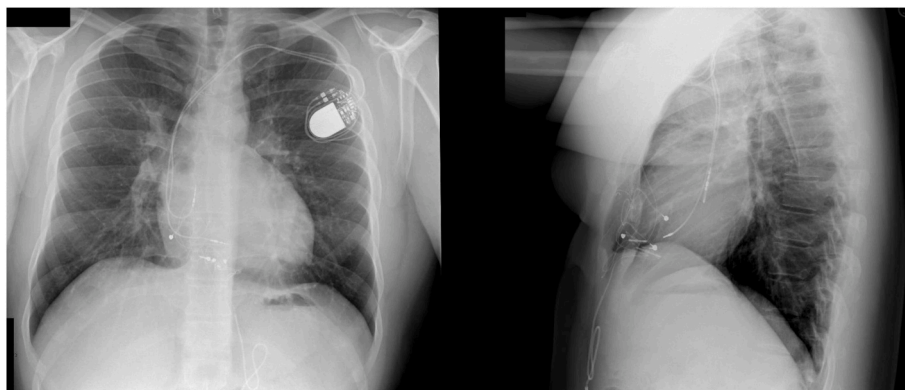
2-view chest Xray of dual chamber transvenous leads.
